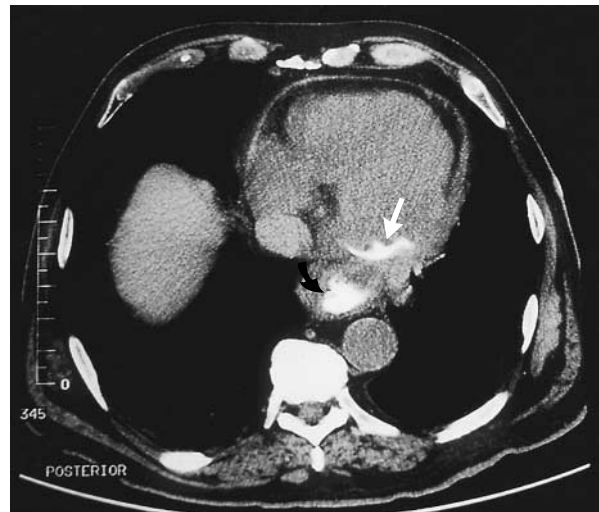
Computed Tomographic Scan of the Chest Obtained after the Oral Administration of Contrast Material.
